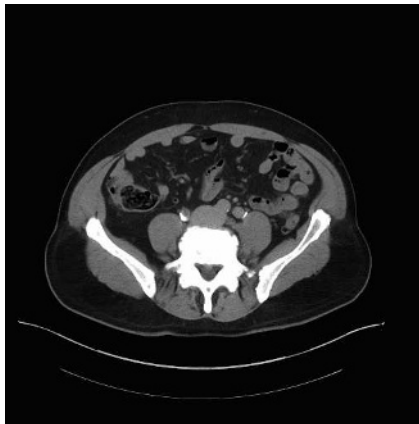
CT of abdomen and pelvis demonstrating filling defect (cross-section and three-dimensional reconstruction).
